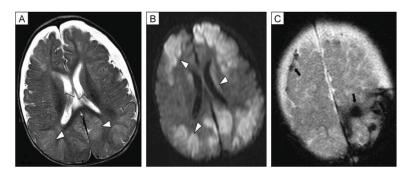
Predominantly post-traumatic hypoxic-ischemic injury pattern in a 4 month old infant with abusive head trauma. A, MRI T2-weighted image demonstrating multiple foci of subtle hyperintensity and loss of gray-white differentiation in watershed zones and the putamen (arrow heads), as well as chronic subdural hygromas. B, Diffusion-weighted image showing corresponding multiple confluent areas of restricted diffusion (arrow heads). C, Susceptibility-weighted sequence showing acute extra-axial hemorrhage over the convexity posteriorly and frontally (arrows). Reprinted with permission from J Neurotrauma 2007;24:106–18.
